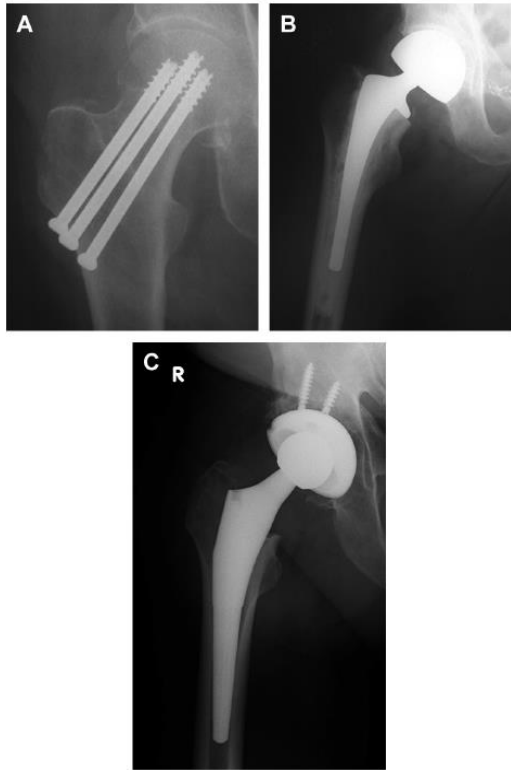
Anteroposterior radiographs showing treatment options for a femoral neck fracture. (A) Cannulated screws. (B) Hemiarthroplasty. (C) Total hip arthroplasty.
